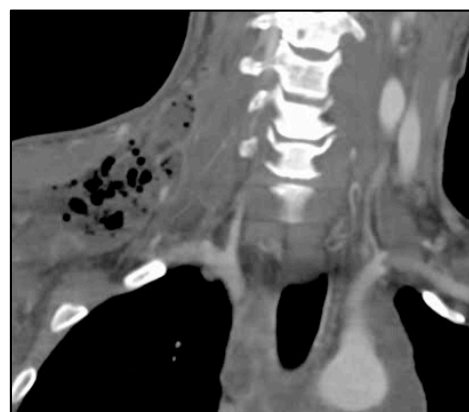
Neck CT with contrast, coronal view
